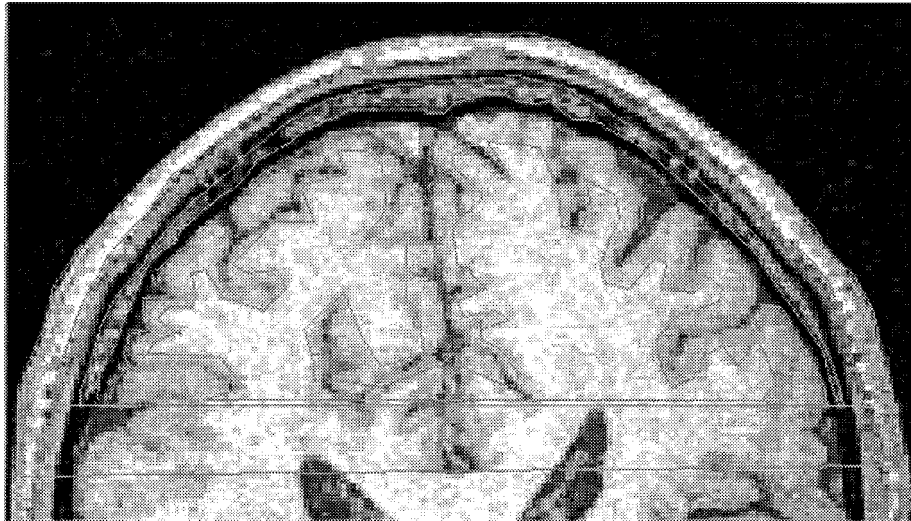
A MRI scan with manually generated outlines.
